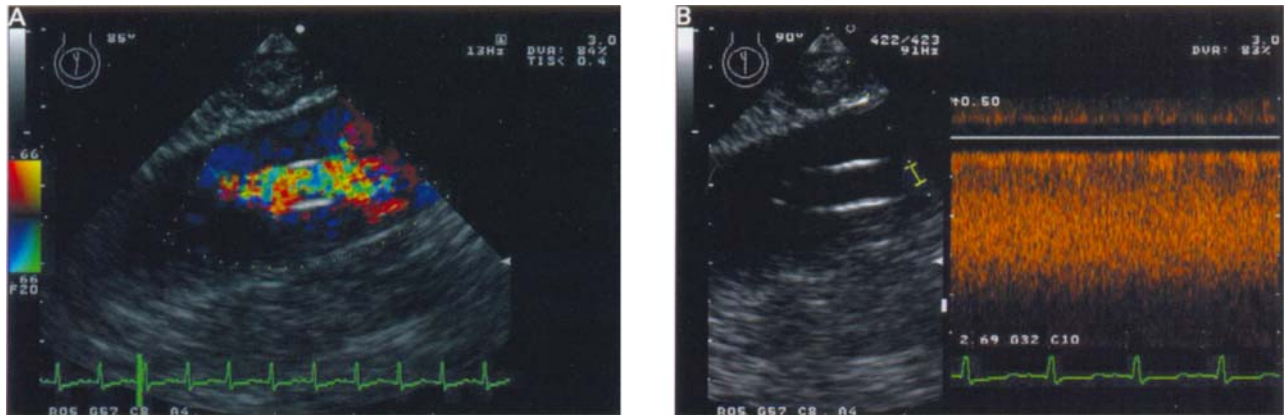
Outflow cannula of a centrifugal pump positioned in the ascending aorta, imaged in the long-axis view. (A) Colour flow Doppler shows a turbulent outflow velocity profile, whereas (B) pulsed wave Doppler recording shows continuous flow with a maximum velocity of 1.6 m/s.
